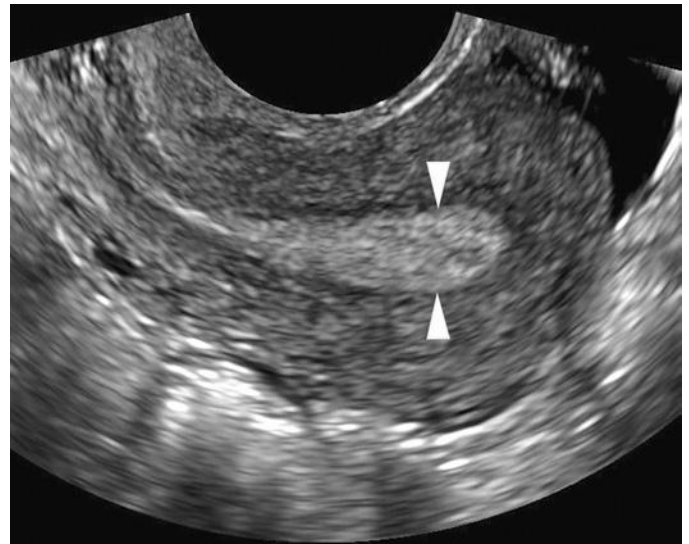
A 25-year-old woman referred for sonographic evaluation for oligomenorrhea. Longitudinal transvaginal sonographic image of the retroverted uterus shows a normal homogeneous endometrial echo complex measuring 8 mm in thickness. Standard measurement of the endometrium is performed at its thickest part (arrowheads) in the mid-sagittal plane.
